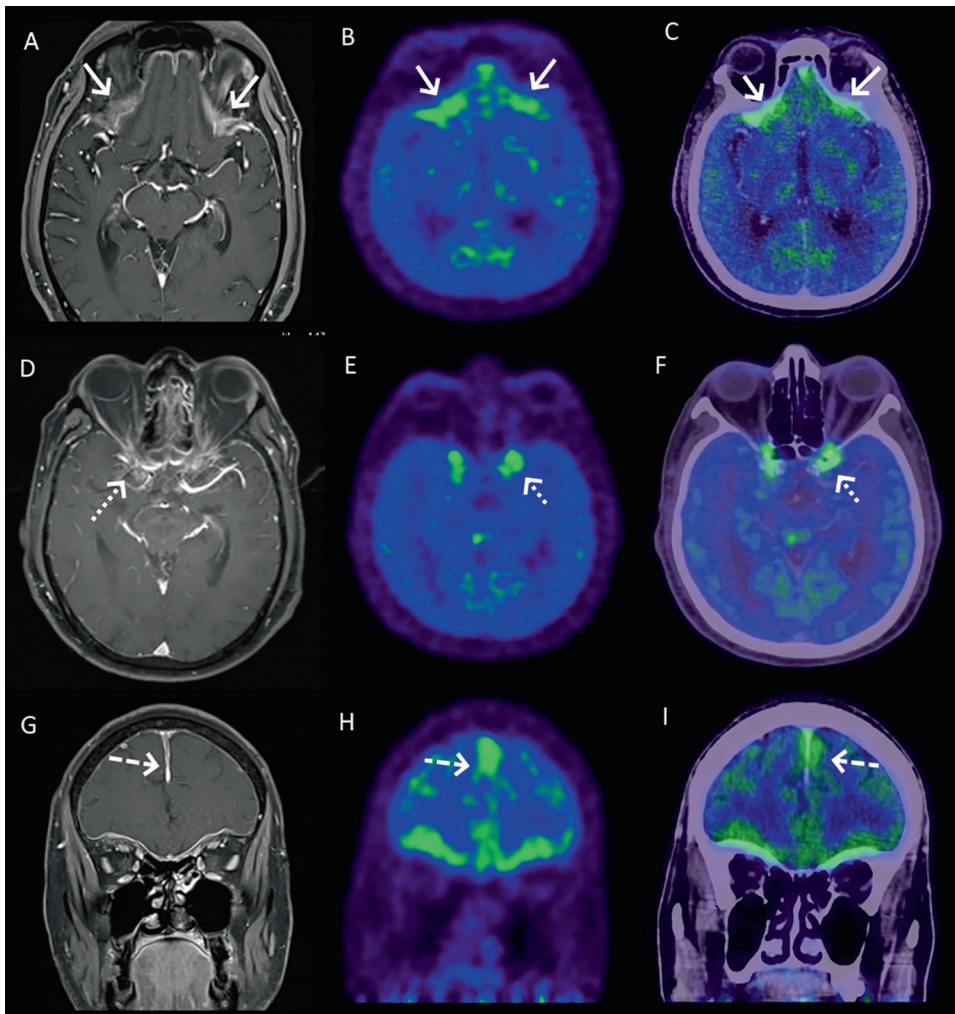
Axial and coronal magnetic resonance imaging (gadolinium-enhanced T1-weighted imaging sequence), positron emission tomography, and fused positron emission tomography-computed tomography images show metabolically active thickening with enhancement involving the supraorbital pachymeninges (maximum standardized uptake value [SUVmax]-4; A–C), bilateral optic sheaths (SUVmax-4.5; D–F), and dura mater of falx cerebri (G–I).
